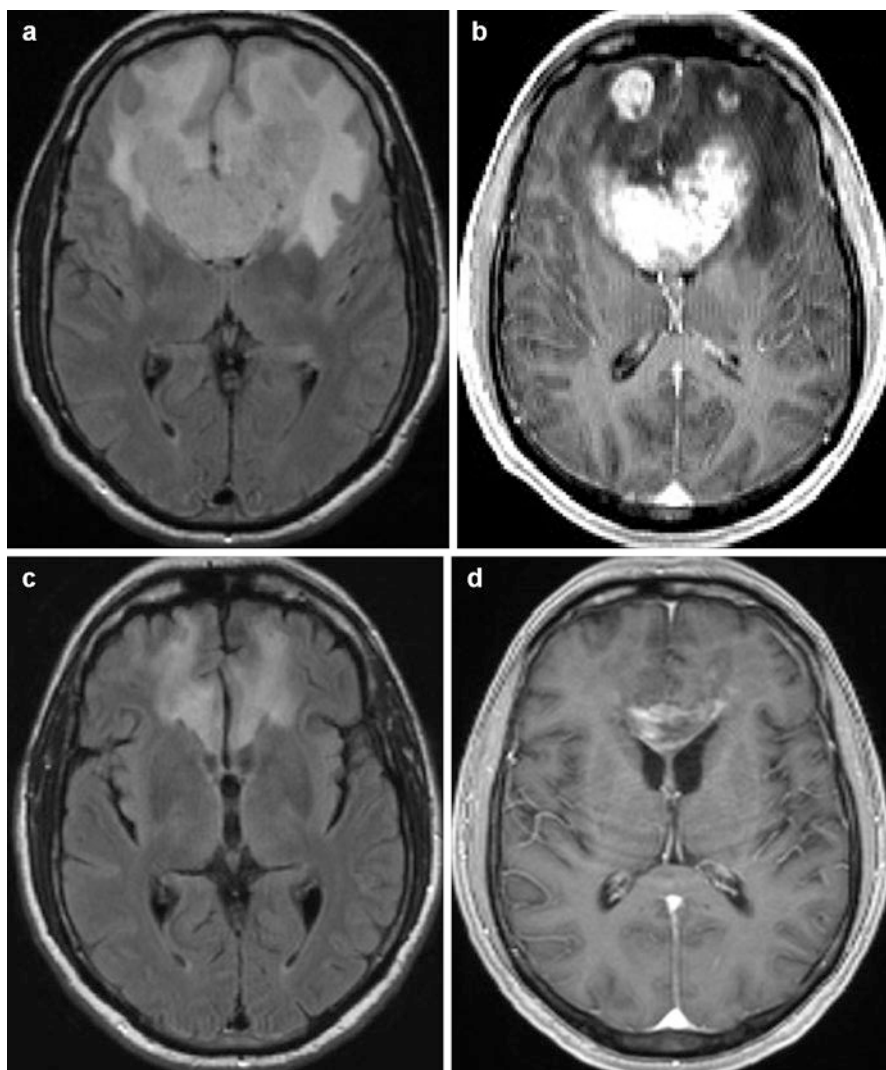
(a, b) Magnetic resonance image (MRI) of an elderly male patient (71 years old) with newly diagnosed glioblastoma multiforme (GBM). Flair sequence shows a large and oedematous hyperintense lesion infiltrating both frontal lobes and corpus callosum (a). T1-weighted axial gadolinium-enhanced MRI showing two contrast enhancing lesions in the setting of a multicentric GBM (b). (c, d) Follow-up MRI from the same patient after six cycles of treatment with temozolomide. Flair sequence shows a marked reduction of the oedema (c). Dramatic improvement of the contrast enhancement lesions is observed after the administration of gadolinium (d). The patient presented a neurological improvement and the KPS increased from 50 to 70%. The overall survival was 18 months
